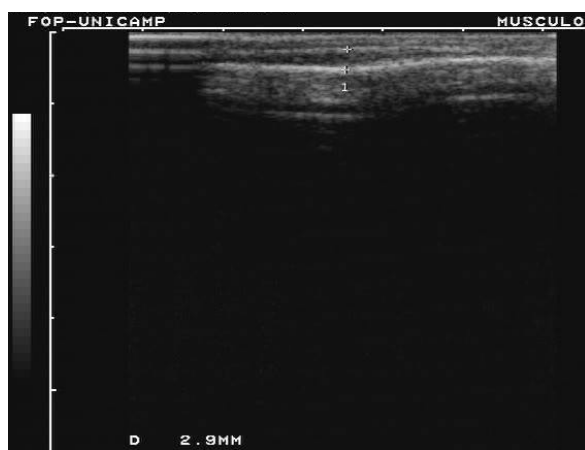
Caso clínico 2: imagem ultrasonográfica da porção anterior do músculo temporal (lado direito) em repouso (fase 1).
